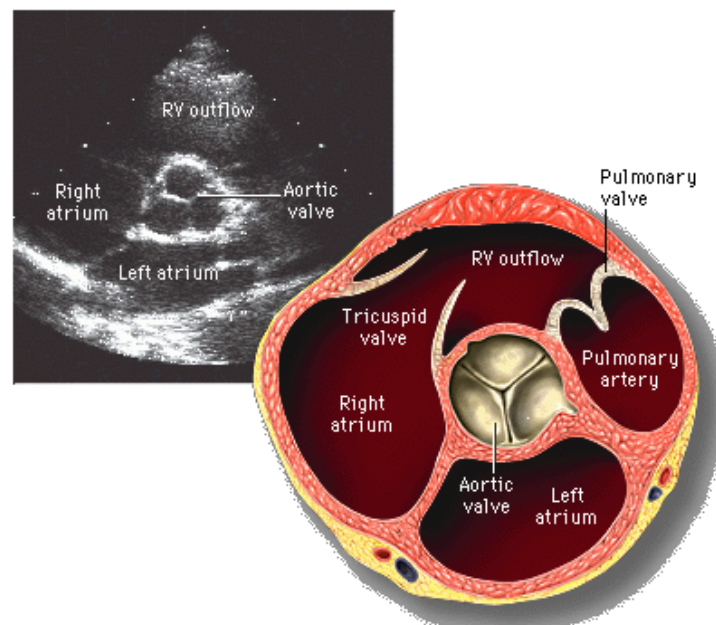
Normal parasternal short axis view .(Feigenbaum2010)
